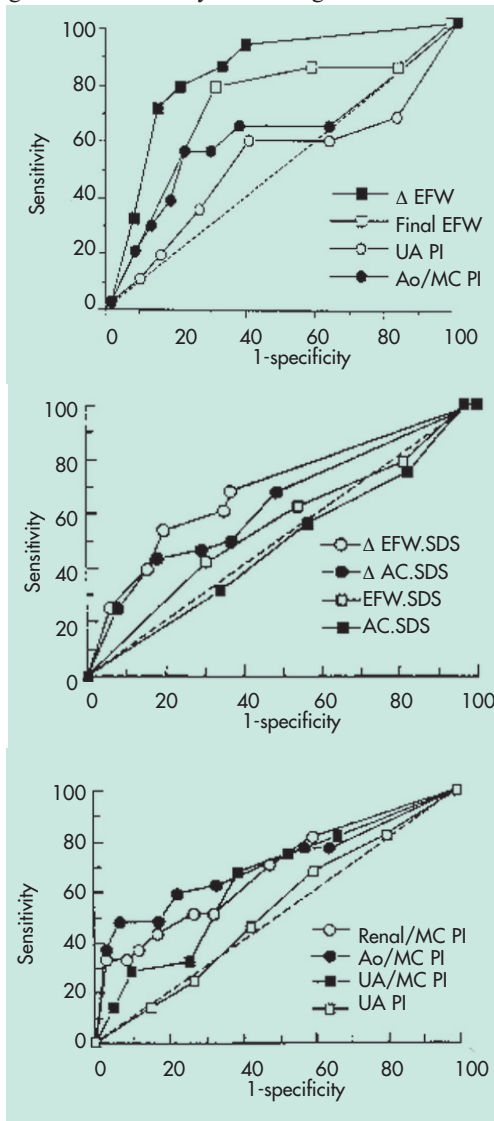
a. Receiver operating characteristic curves in the prediction of abnormal mid arm circumference: head circumference ratio. From Chang et al (1993). EFW = estimated fetal weight;  $\Delta$  EFW = change in standard deviation score of estimated fetal weight; UA = umbilical artery; PI = pulsatility index; Ao = aortic; MC = middle cerebral. b. Receiver operating characteristic curves of measurement of fetal growth (change in  $\Delta$ ) standard deviation score (SDS) values of abdominal circumference (AC) and estimated fetal weight (EFW) in the prediction of adverse perinatal outcome. c. Receiver operator characteristic curves of SD score of final fetal doppler waveform indices in the prediction of adverse perinatal outcome. From Chang et al (1994). Ao = Aortic; MC = middle cerebral; UA = umbilical artery; PI = pulsatility index.
